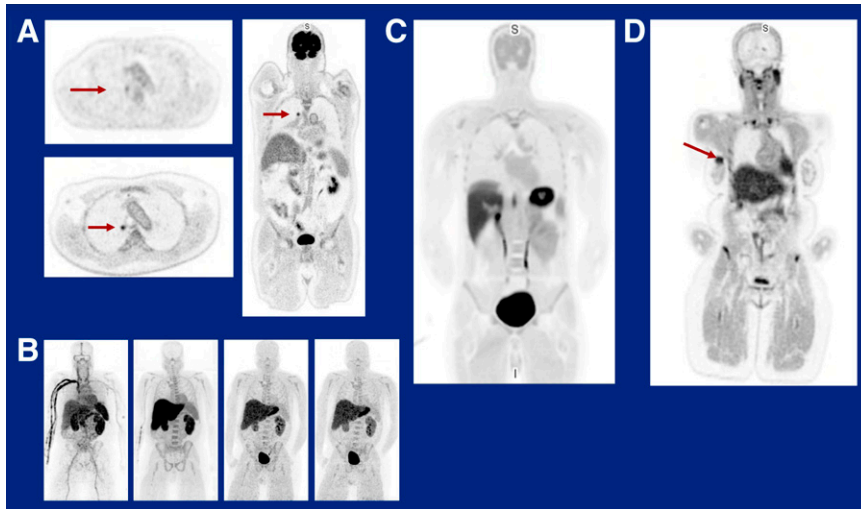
Human research studies on the PennPET Explorer with extended axial coverage. Whole-body imaging with: (A) ^{18}F -FDG in lung cancer, with insets of (top) standard-of-care imaging at 1 h after injection and (bottom) PennPET Explorer imaging at 2 h 20 min after injection; (B) ^{11}C -trimethoprim in infection imaging (left to right) at 50–69 s and 7–8, 90–95, and 120–130 min; (C) ^{18}F -FNOS for assessment of lung inflammation (normal subject); and (D) ^{18}F -fluoroglutamide in breast cancer. The increased sensitivity afforded by the extended axial coverage provides possibilities for a wide range of clinical and research applications.
